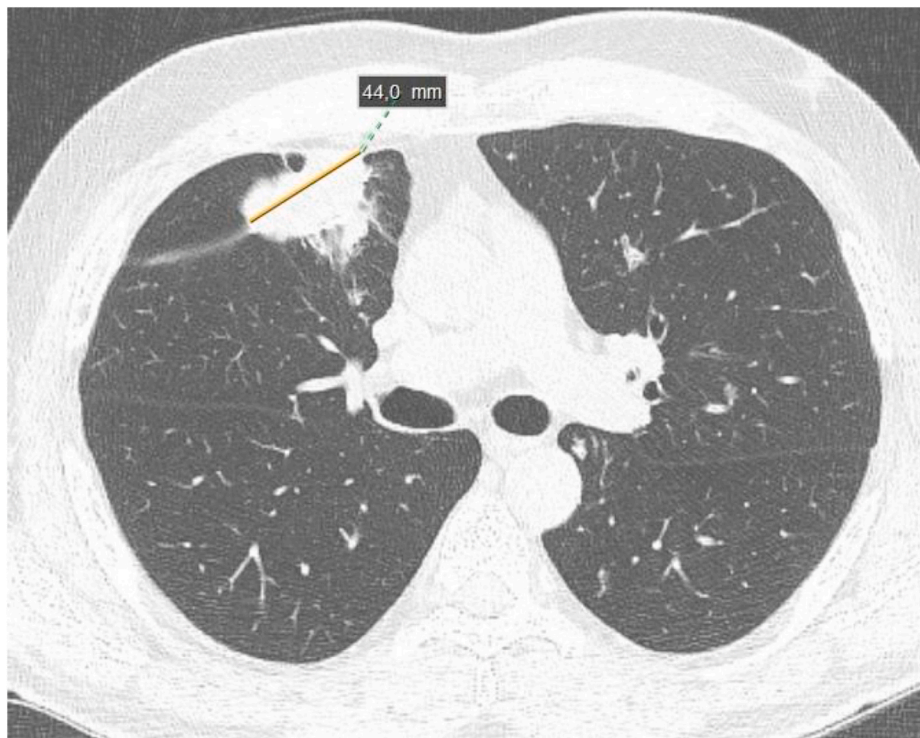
Computed tomography scan showing a tumour with 44 mm in maximal diameter in the right lung.
